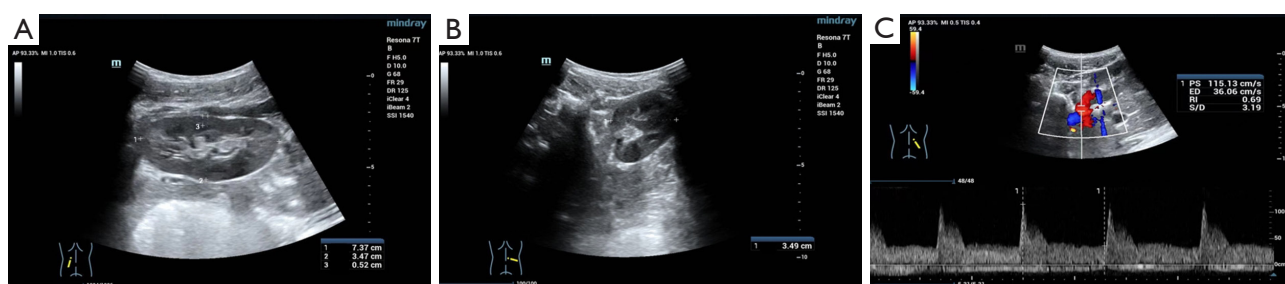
Renal ultrasound examinations. (A,B) Measurement of renal size and cortical thickness using two-dimensional grayscale ultrasound. (C) Doppler ultrasound measurement of right renal artery hemodynamic parameters including peak systolic velocity and resistance index. PS, peak systolic velocity; ED, end-diastolic velocity; RI, resistance index; S/D, peak systolic velocity/end-diastolic velocity.
